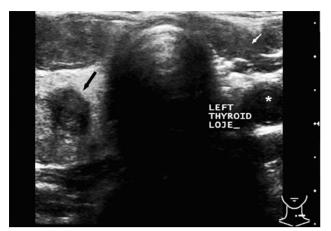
Transverse ultrasound image shows that the left thyroid lobe is absent (white arrow). Ipsilateral common carotid artery (asterisk) and a hypoechoic nodule of the right thyroid lobe (black arrow) are also visible.
